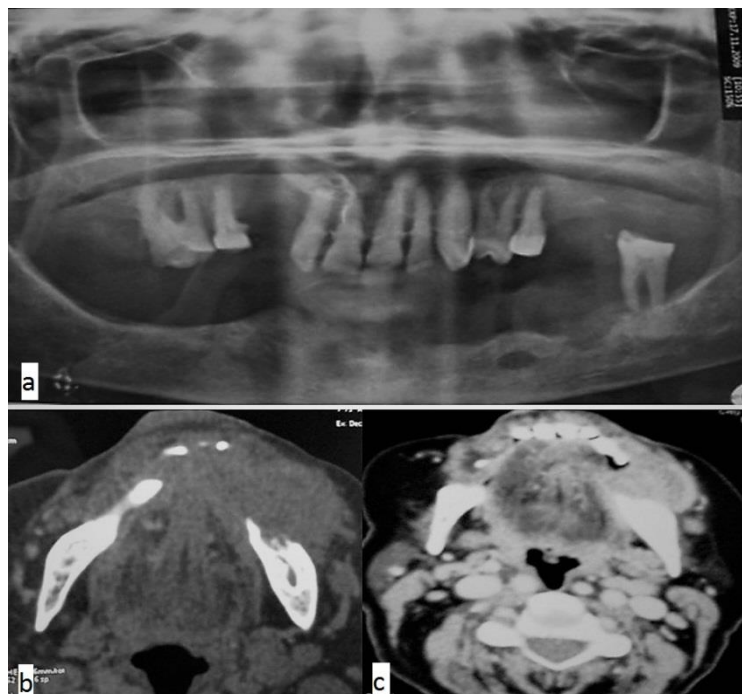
(a) Panoramic radiograph revealing a destruction of the alveolar bone; (b) computed tomography (CT) scan: hard-tissue window showing an aggressive destruction of mandibular alveolar bone; (c) soft-tissue window revealing bilateral cervical lymph nodes were enlarged.
